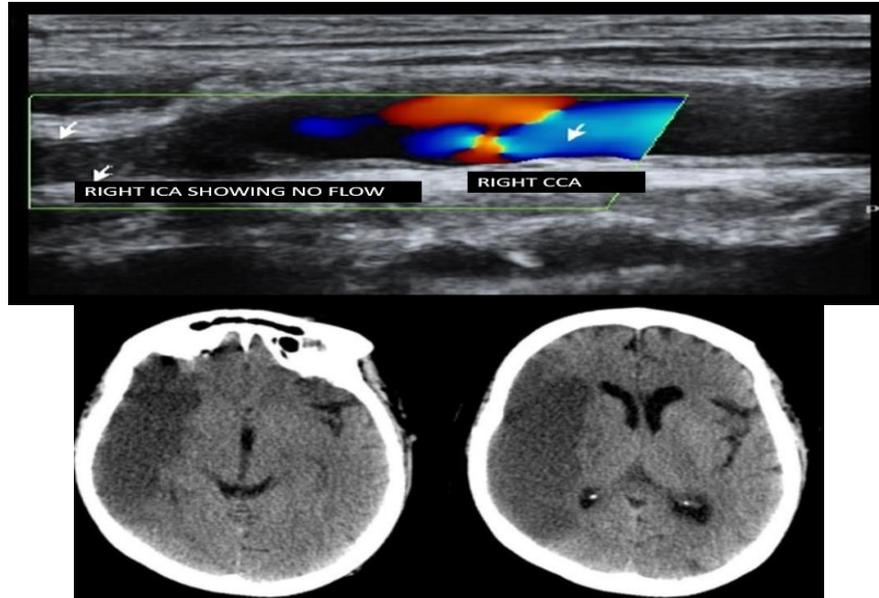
Image showing no flow in right ICA due to thrombus and corresponding CT brain shows malignant right MCA infarct
